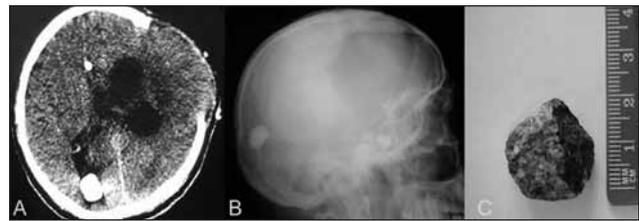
(A) CT scan and (B) x-rays of a patient with a right occipital stone caused by landmine explosion. The diameter of the stone was approximately 2 cm (C).
